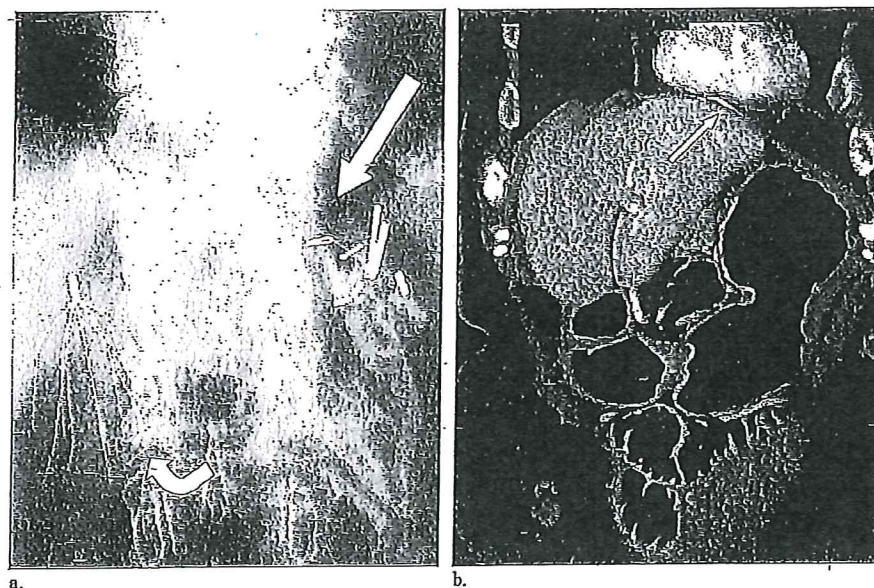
Posteroanterior abdominal radiograph (a) and coronal view of volume-rendered CT image (b) demonstrate a fractured short limb (arrows) that migrated to the pericardial space. In addition, there is a fractured long limb (curved arrow) inferior and medial to the main body of the filter (a).
